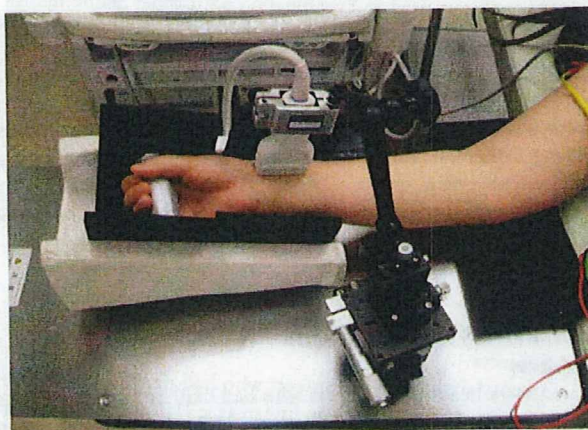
Ultrasound monitoring of radial artery by using a special probe holder.
